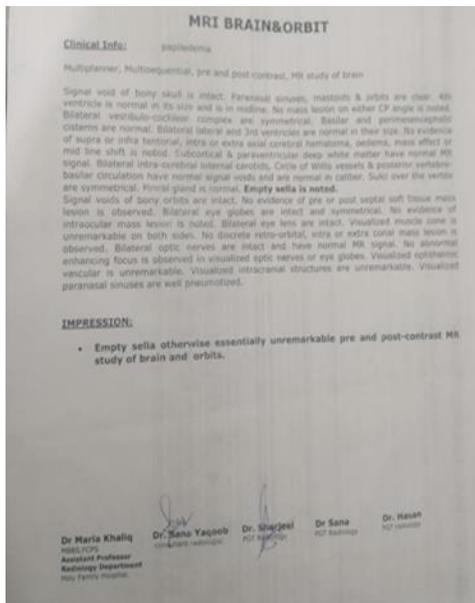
MRI Brain + Orbit (Report)
